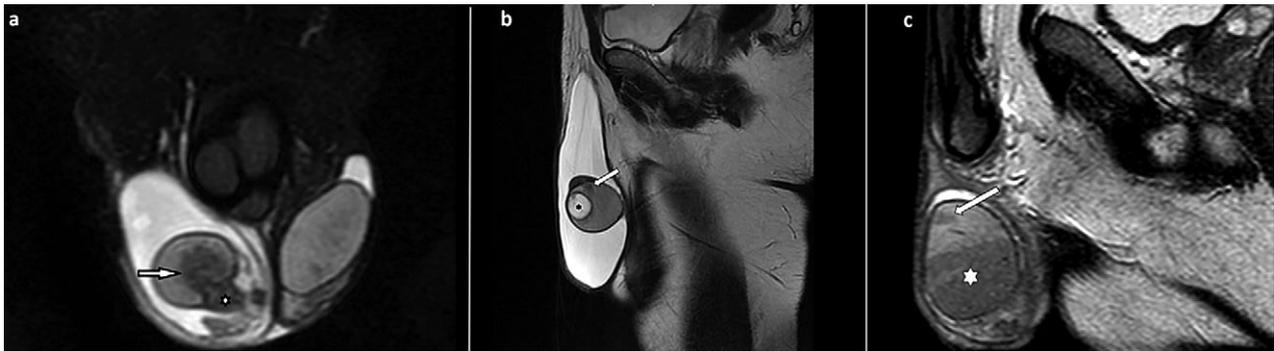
The coronal T2-weighted fat-suppressed image of a 13-year-old patient with BEO (a). The head of the epididymis (star) is swollen and hypointense. In the testicular parenchyma adjacent to the epididymis is a focal hypointense lesion (arrow) accompanied by a hydrocele. The sagittal T2-weighted fat-suppressed image of a 36-year-old patient with BEO (b), showing the presence of an abscess (star) and an adjacent hypointense focal lesion (arrow) accompanied by a hydrocele. The sagittal T2-weighted fat-suppressed image of a 24-year-old BEO patient (c), demonstrating the focal involvement of the right testis (star) and a second focal lesion (arrow).
